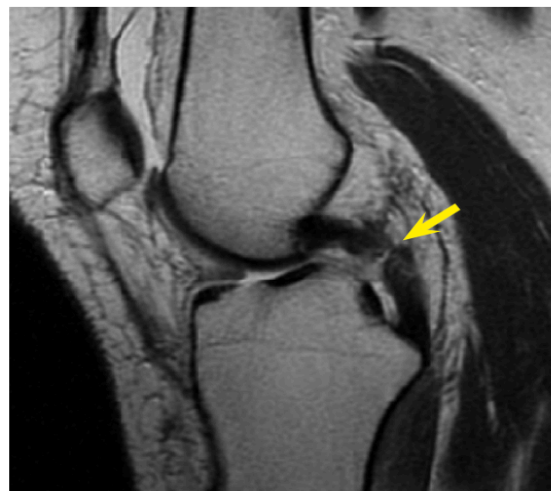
Sagittal T1 MRI demonstrating a torn PCL
